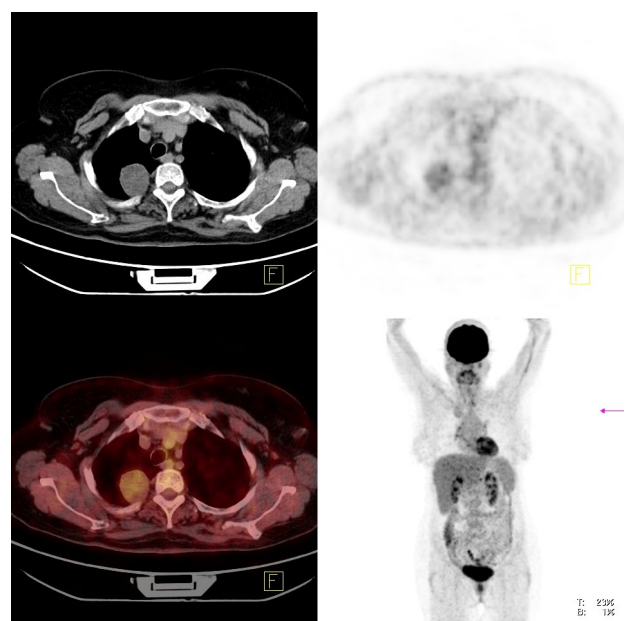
PET-CT image shows increased FDG uptake (SUVmax:3.2) of a 4 cm lesion in upper lobe of right lung
